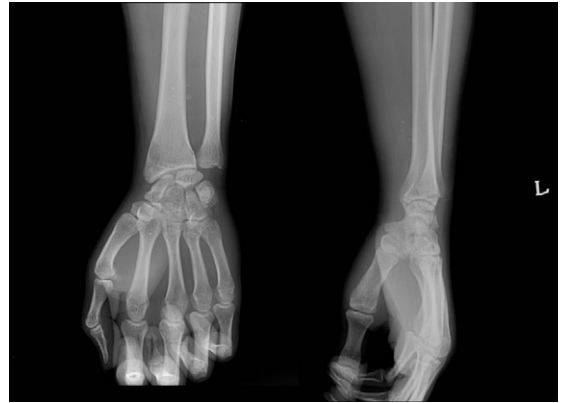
Plain radiograph shows soft tissue swelling with small round calcification in distal forearm.
